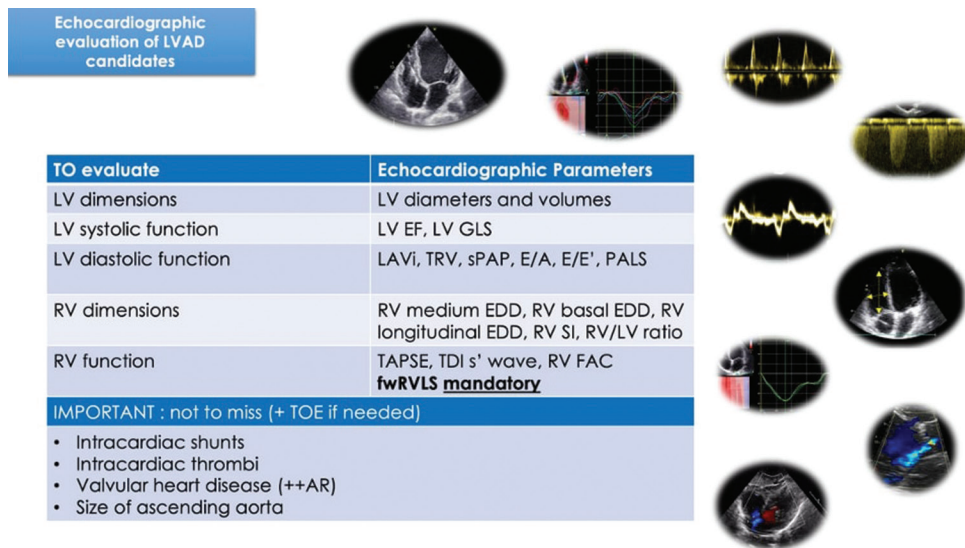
Echocardiographic parameters to evaluate in Left ventricular assist device (LVAD) candidates. The echocardiographic evaluation of patients referred for LVADs should start with transthoracic echocardiography and should focus on the evaluation of left ventricle (LV) systo-diastolic function and RV dimensions and function. RV study could not exclude the application of speckle tracking echocardiography to measure RV-free wall strain. Moreover, particular attention should be paid to the exclusion of intracardiac shunts or thrombi, severe valvular heart disease (above all, aortic regurgitation, mitral stenosis and tricuspid regurgitation) and to the measures of ascending aorta size; the application of transoesophageal echocardiography may be necessary to improve the assessment of these elements. FAC = Fractional area change, EDD = End-diastolic diameter, GLS = Global longitudinal strain; LAVi = Left atrial volume index, LV = Left ventricle, sPAP = Systolic pulmonary artery pressure, RV = Right ventricle, s' = Systolic velocity wave by tissue-Doppler imaging, SI = Sphericity index, TAPSE = Tricuspid annular plane systolic excursion, TDI = Tissue Doppler imaging, TRV, Tricuspid regurgitant velocity
